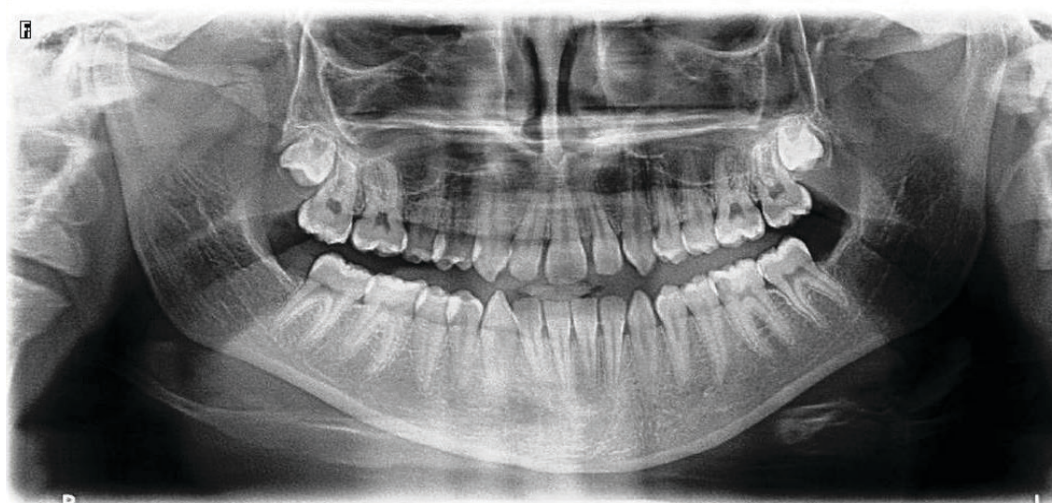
Patient's panoramic radiography.
